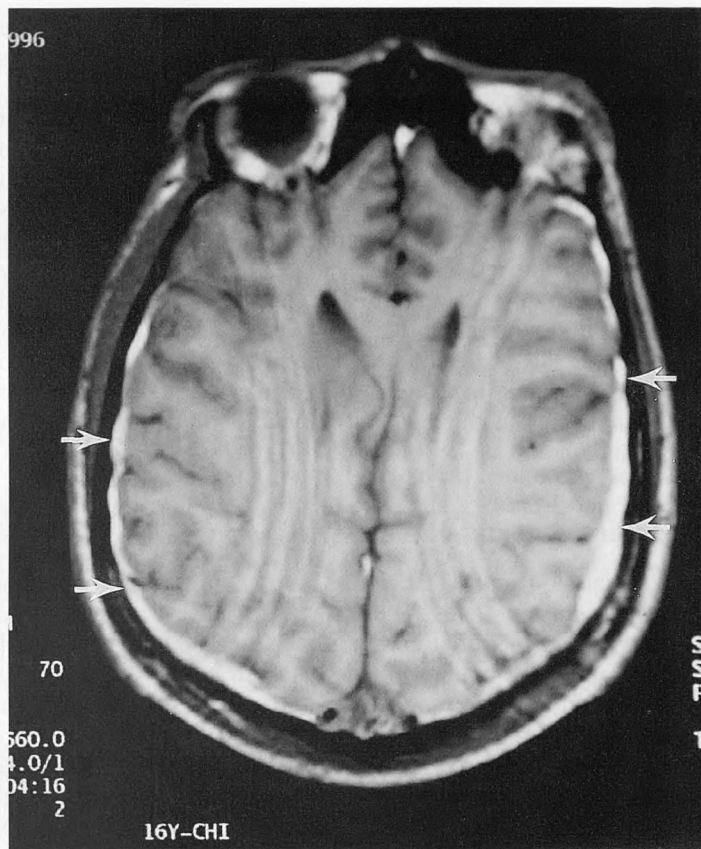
MRI of a high school football player with persistent headaches and poor school performance. Although the CT scan was normal, the MRI demonstrated small bilateral subdural hematomas, thus documenting the presence of an injury.
